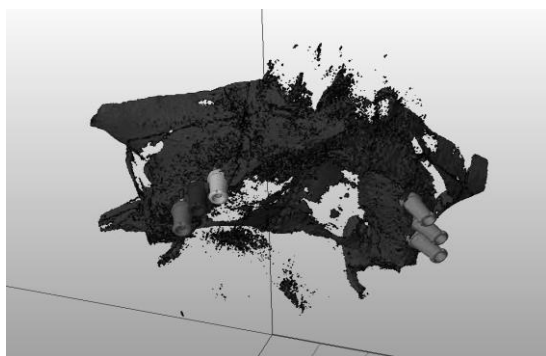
The full engagement of the implants in the bone has been checked on the virtual model created on the basis of CBCT.
